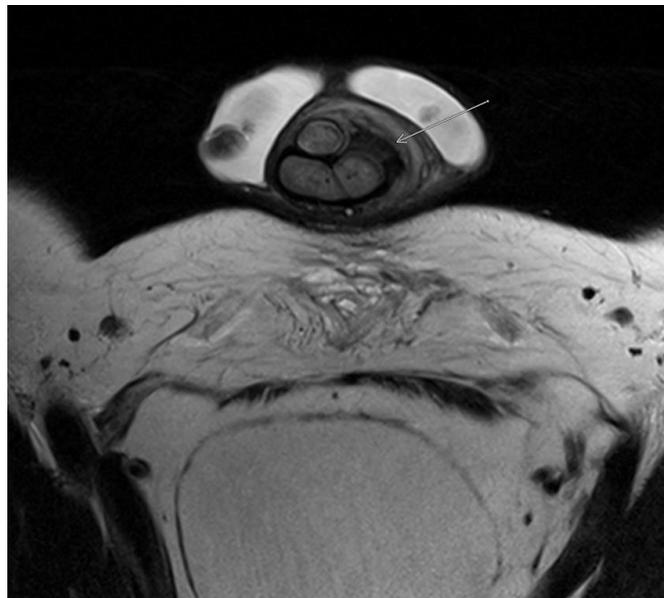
Axial T2 MRI Tunical Disruption.
